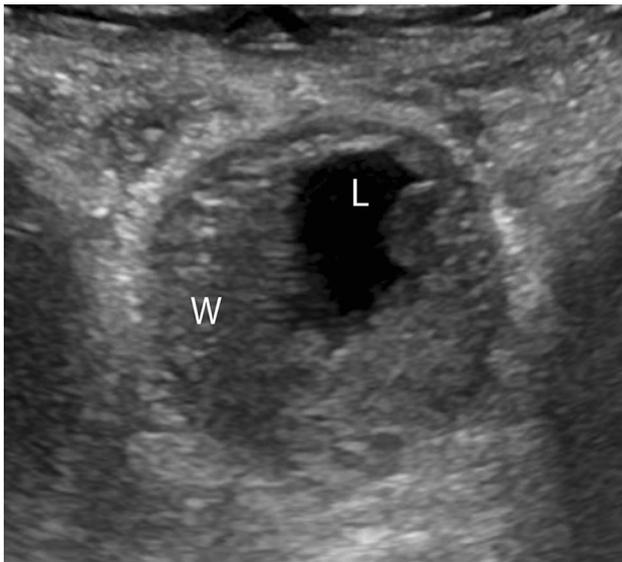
50-year-old male with history of chronic lymphocytic leukemia and cyclophosphamide-induced cystitis. Transverse ultrasound image of the bladder shows severe bladder wall thickening, which results in marked restriction of bladder distension, resulting in a small bladder lumen. *W* bladder wall; *L* bladder lumen
